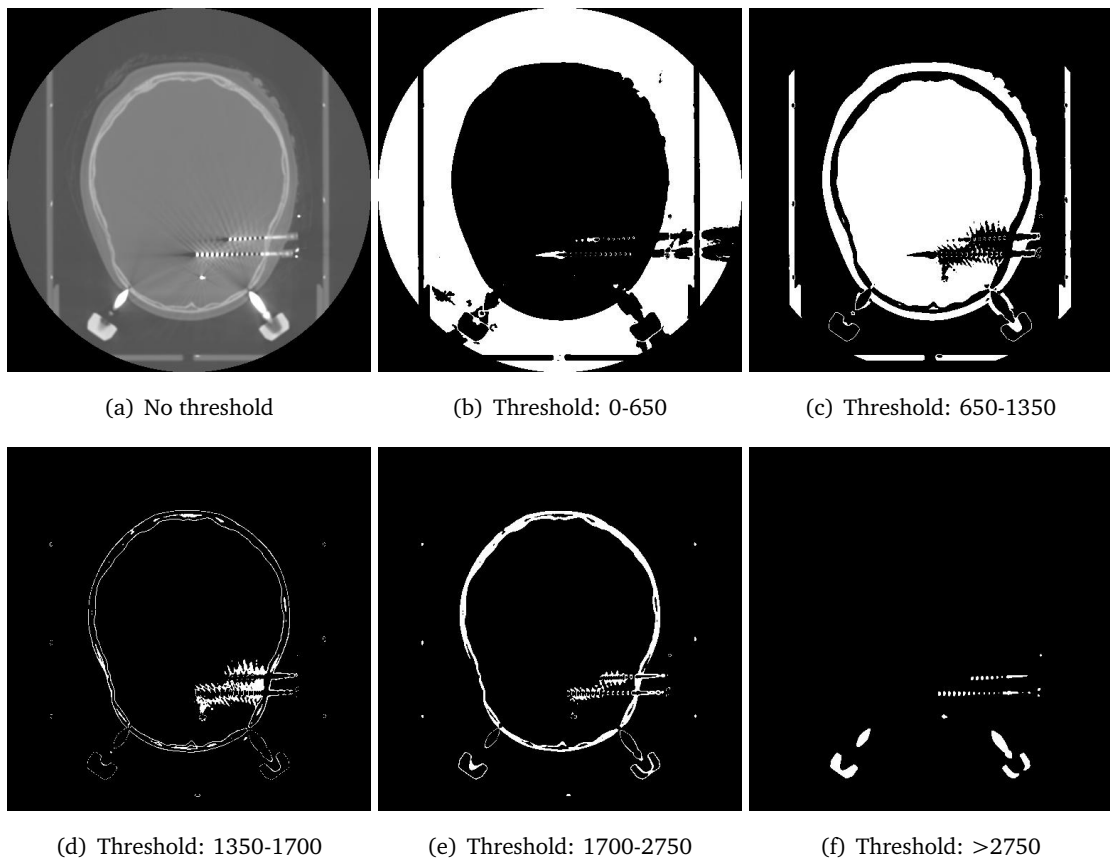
Intensity threshold of a CT slice. (a) original slice without any thresholding; (b) background; (c) soft tissue, including skin, brain and some stereotaxic frame artifacts; (d) outer boundaries of skull and soft skull tissue; (e) hard skull tissue; (f) artifacts like electrodes, screws, wires and stereotaxic holding frame.
